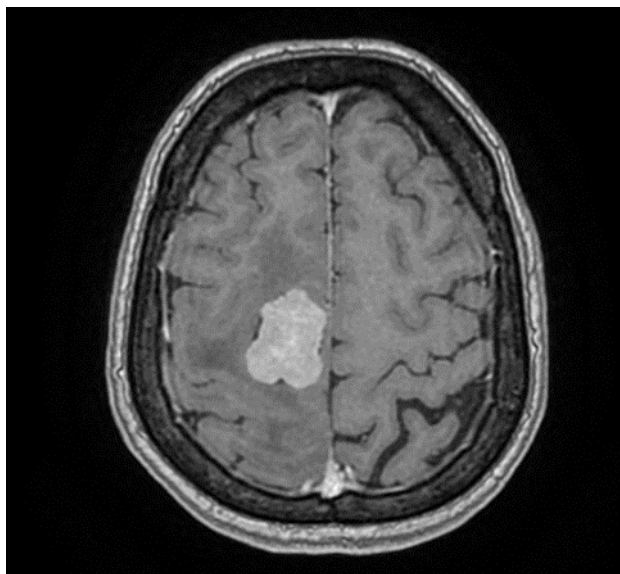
MRI brain (T1 image).
